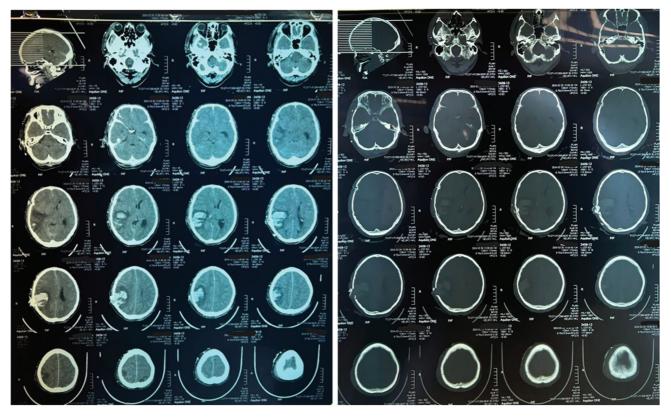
Computed tomography (CT) of the brain of Mr. H showing a right temporal and parietal bleed with areas of comminuted skull fractures and multiple foreign bodies.
